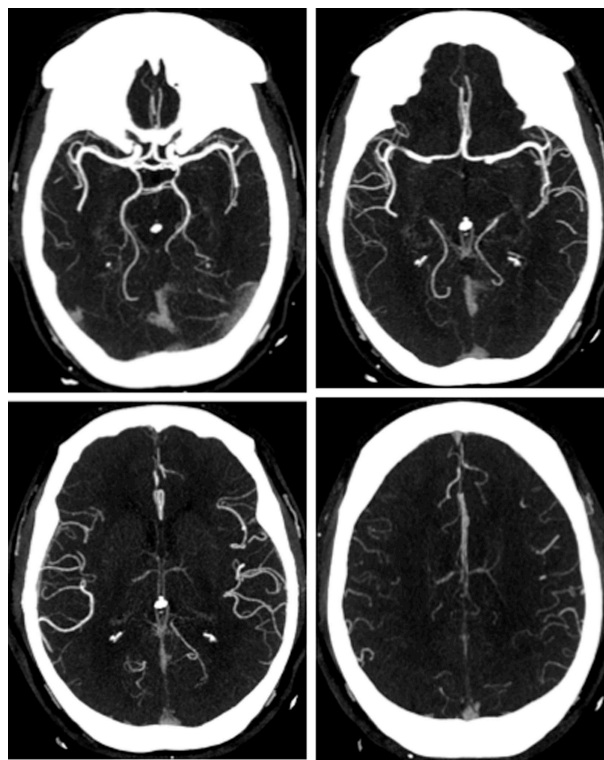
Multiple CT angiogram cuts after five days of the ictus showing increase density of the contrast in the vessel indicating partial resolution of the vasospasm.
